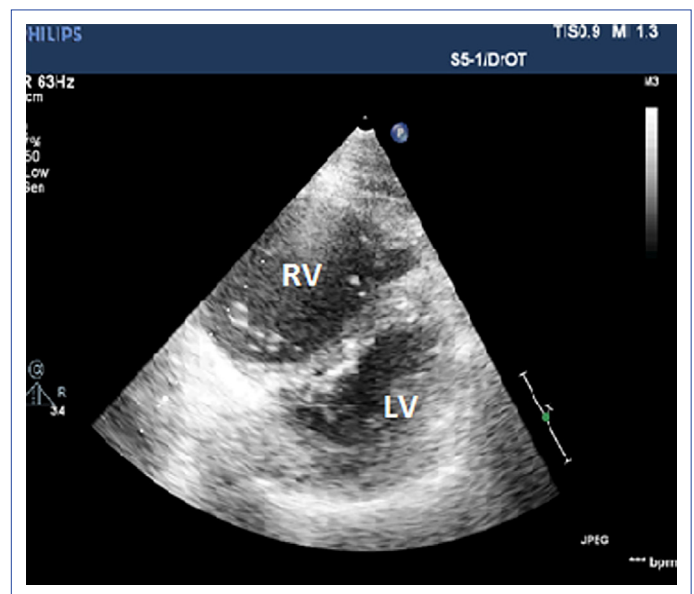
TTE (Apical 4 Ch view). (a) Right ventricle, FAC (fractional area change); EDA (End diastolic Area)-ESA (End systolic Area)/EDA, (Normal 35-60%). (b) Tricuspid regurgitation, RVSP (Right ventricle Systolic Pressure)=SPAP (Systolic Pulmonary Arterial Pressure):  $4VTR2+RAP$
